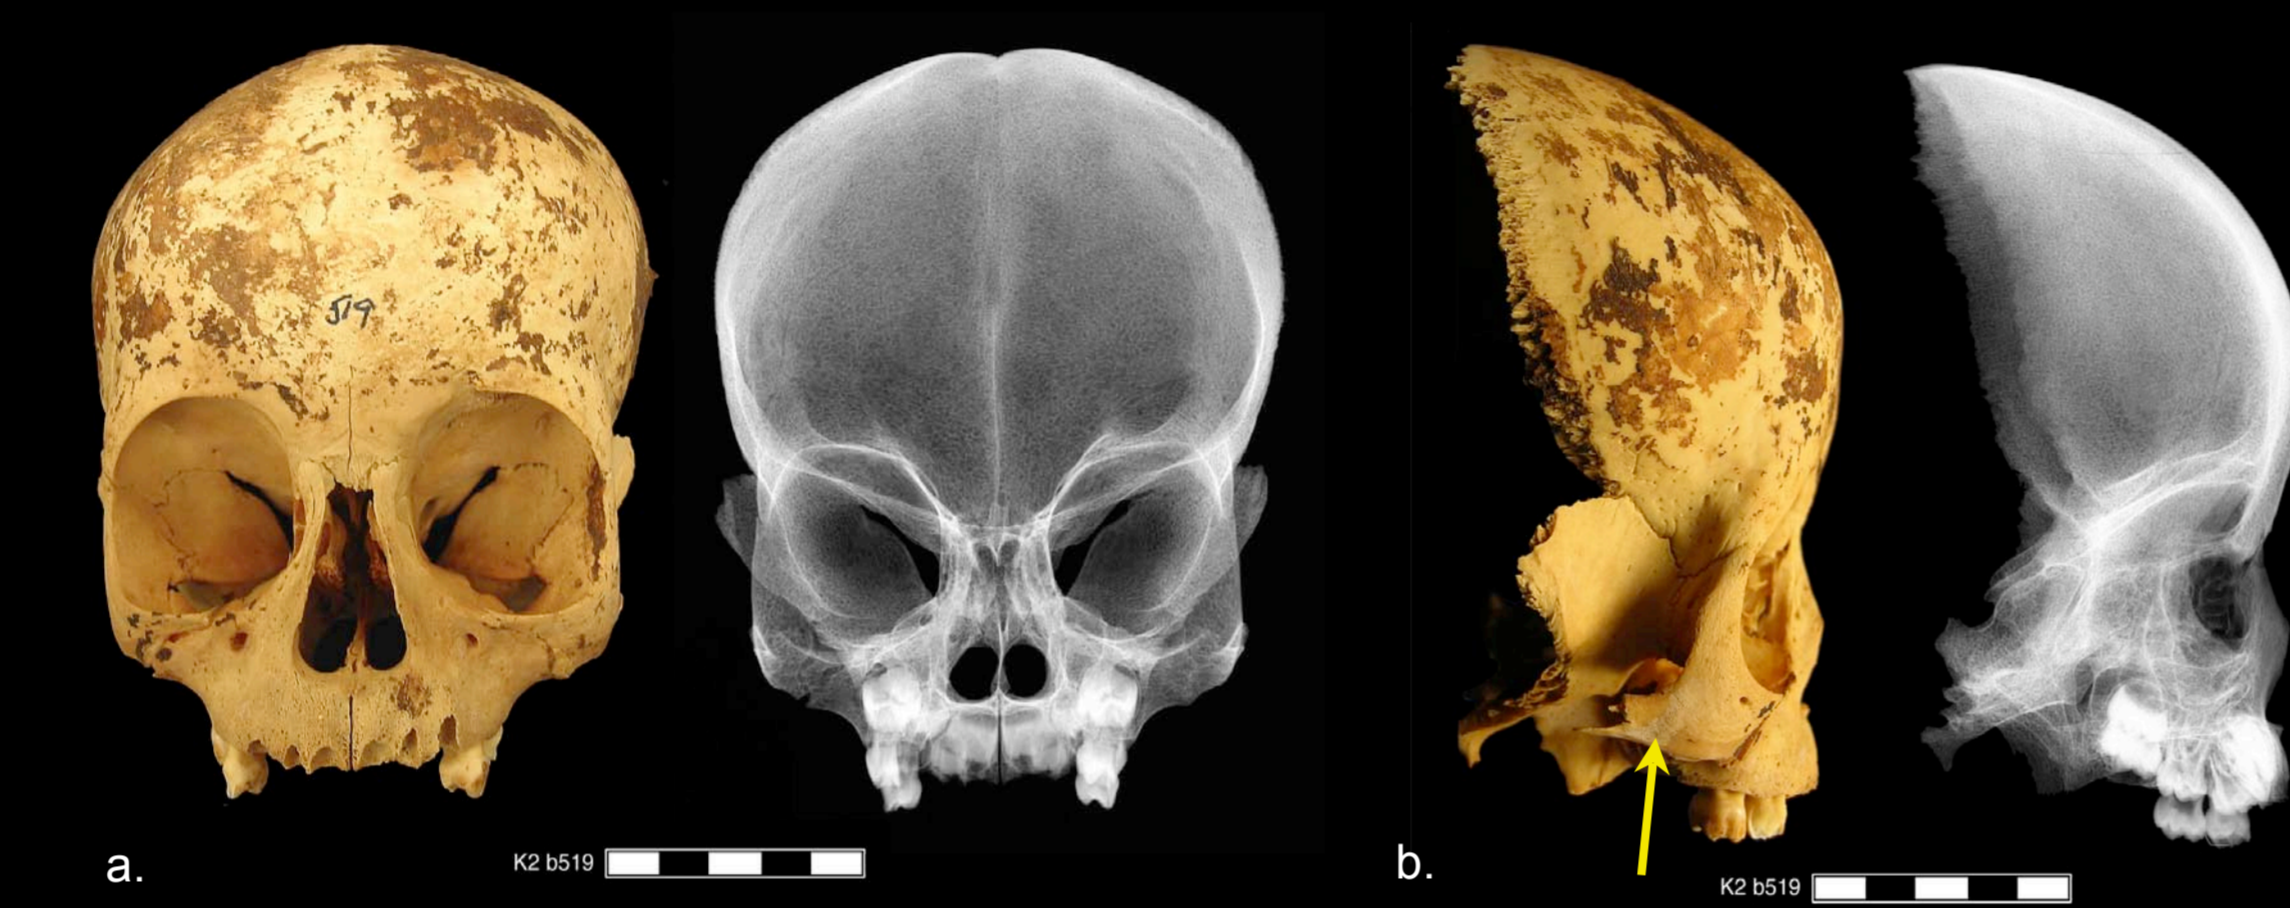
a) Photograph and x-ray showing active cribra orbitalia in both orbits; b) Arrow pointing to slight SPNBF on zygomatic process.
